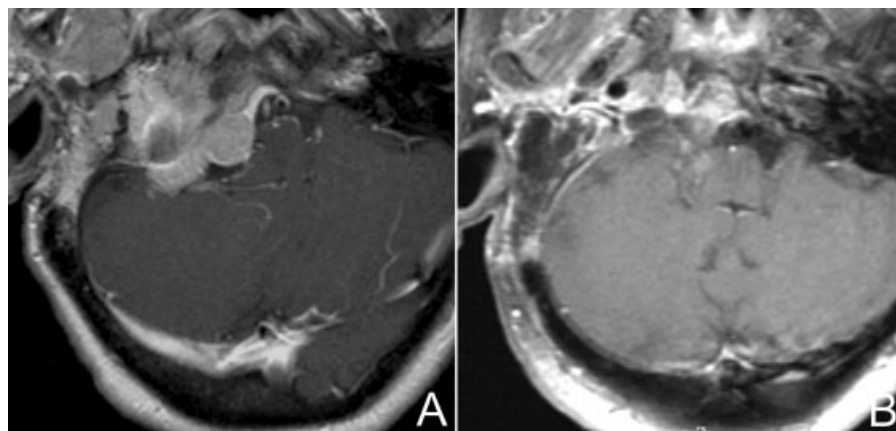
(A) Axial T1-weighted magnetic resonance image with gadolinium enhancement demonstrating a large destructive right-sided skull base lesion extending from the posterior fossa to the cavernous sinus and parapharyngeal space with encasement of the right internal carotid artery and posterior fossa brainstem compression. (B) Three months postoperative axial T1-weighted image demonstrating subtotal tumor resection with decompression of posterior fossa contents.
